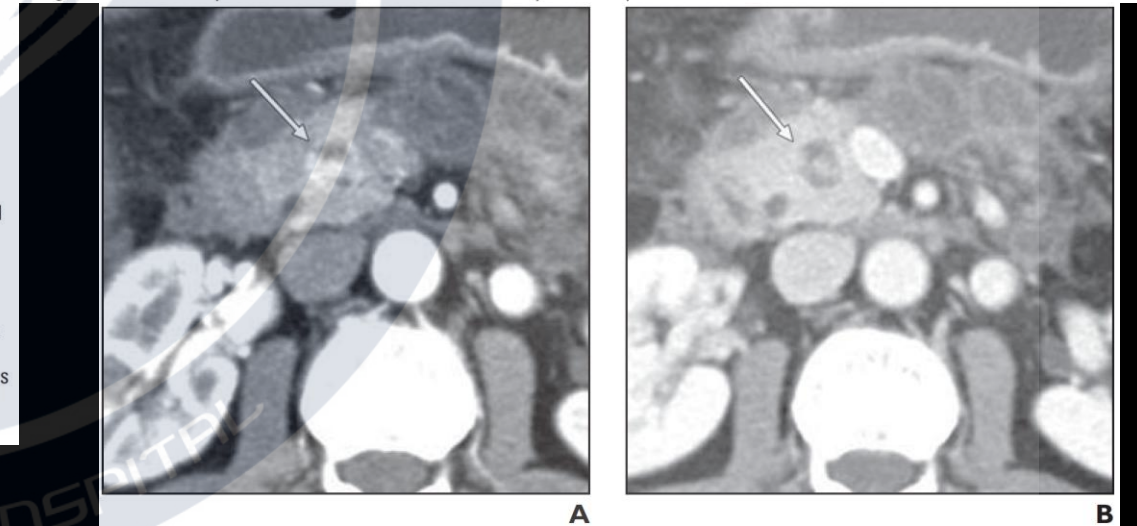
Well-differentiated neuroendocrine tumor (NET), nonfunctioning, in 51-year-old woman. Pancreatic head mass was found on CT performed for evaluation of pancreatitis (case 14 in Table 2).
